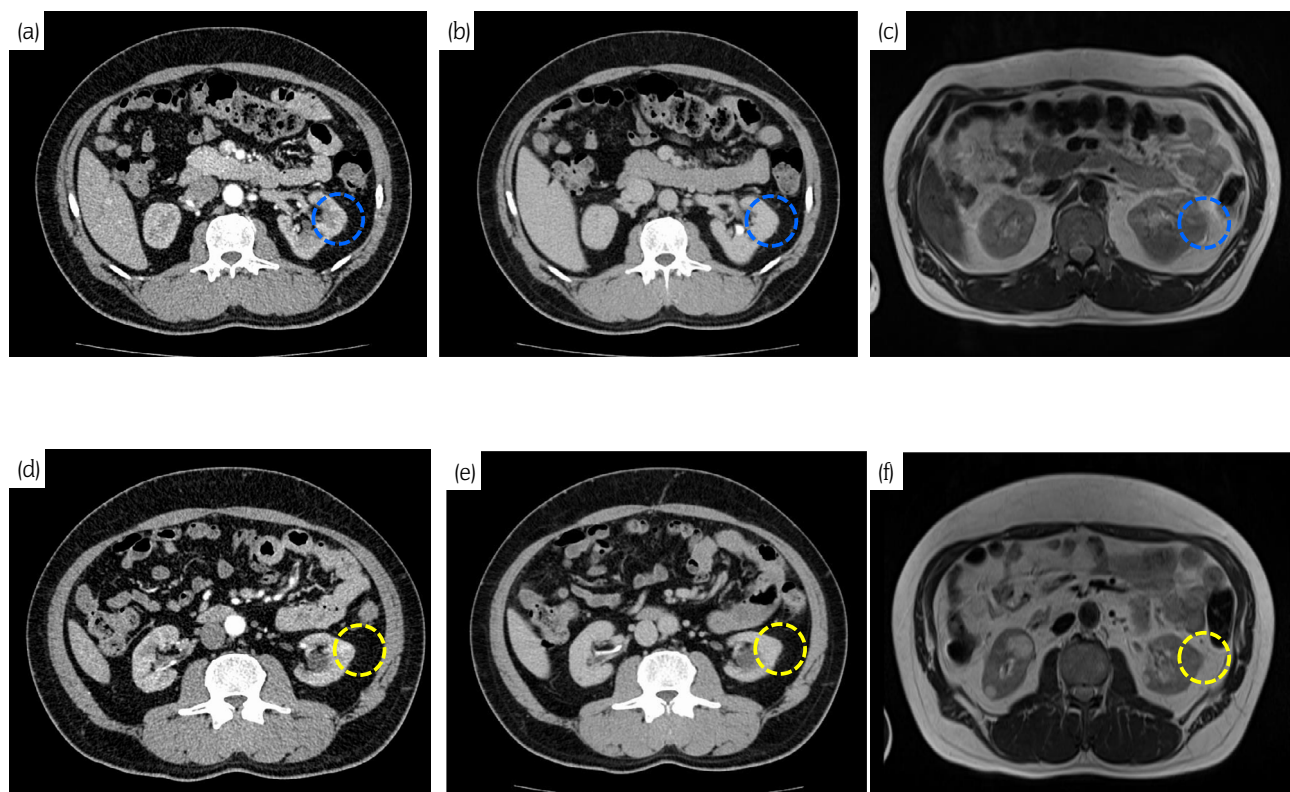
Retrospective analysis of preoperative enhanced CT or MRI did not detect endophytic RCCs. The blue and yellow dot circles indicate the area of lesions that tumors could be detected. (a) Early-phase enhanced CT of the middle pole. (b) Late-phase enhanced CT of the middle pole. (c) MRI of the middle pole. (d) Early-phase enhanced CT of the lower pole. (e) Late-phase enhanced CT of the lower pole. (f) MRI of the lower pole.
